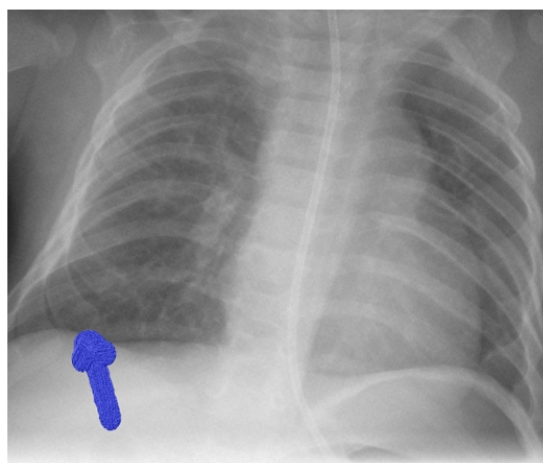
Chest Xray shows widened appearance of ribs distally.
